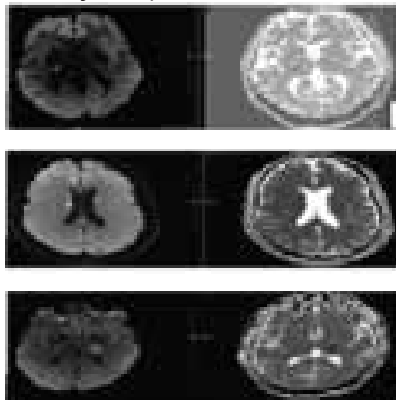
a) Diffusion weighted imaging (DWI) and adjusted Diffusion Coefficient (ADC) of case 1, showing acute infarction of right thalamo-capsular junction/ b) Diffusion weighted imaging (DWI) and adjusted diffusion coefficient (ADC) of case 2, showing acute infarction of right periventricular region. c) Diffusion weighted imaging (DWI) and adjusted diffusion coefficient (ADC) of caes 3, shwoing acute infarction of posterior limb of left internal capsule.
